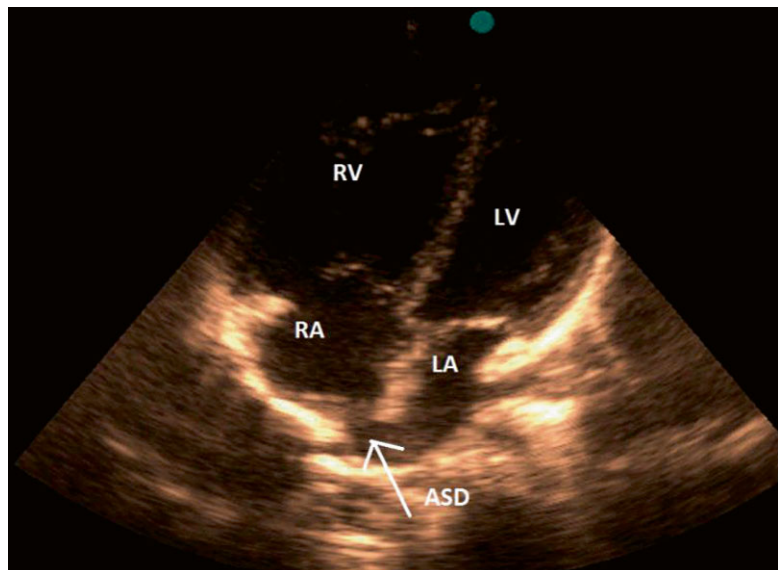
Transesophageal echocardiography (TEE) (0°) in high esophageal view, demonstrating a two-dimensional defect at the superior vena cava to the right atrium and left atrium junction
